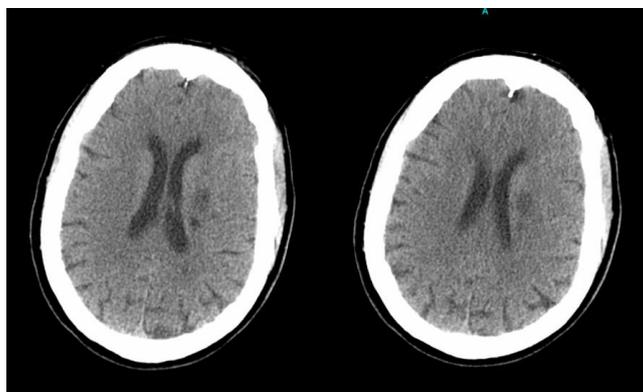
CT scan brain revealing Atrophy and Low density change left basal ganglia suggesting subacute ischemia
